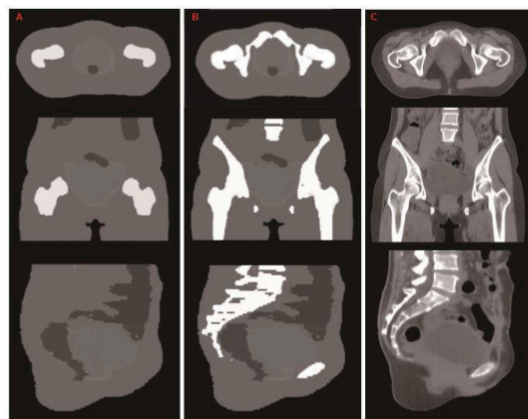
Overview of all the s-CTs used in this study. (A) shows the s-CT generated with only femoral heads, (B) shows the s-CT generated with all the bone regions, (C) shows the original CT.
